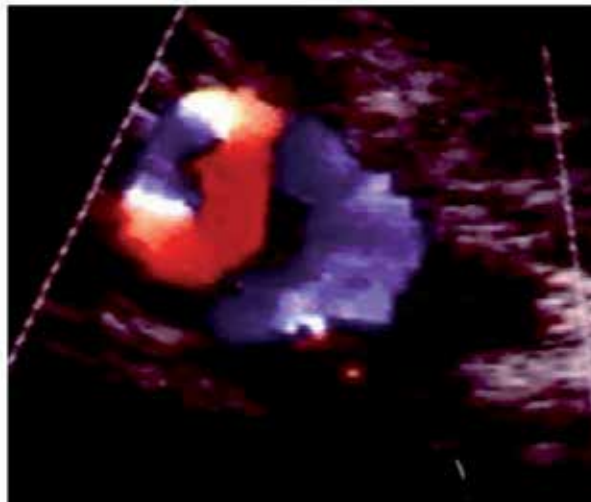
Color flow Doppler imaging shows circular-shaped internal carotid artery
